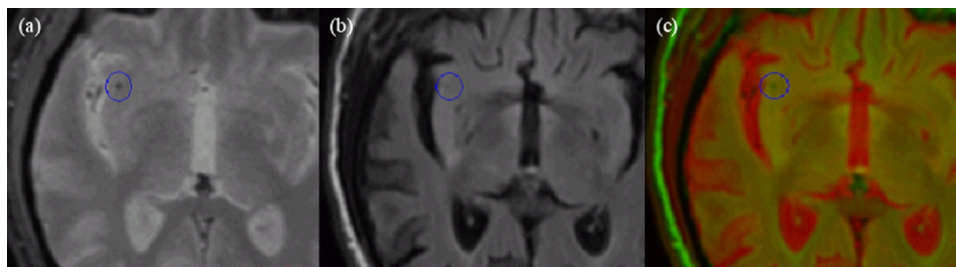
Section of an axial slice of a subject displaying the registration and color fusion (c) of (a) T2*-weighted (T2* W) and (b) fluid-attenuated inversion recovery (FLAIR) images, with a brain microbleed circled in the subcortical white matter located in the right insula.
